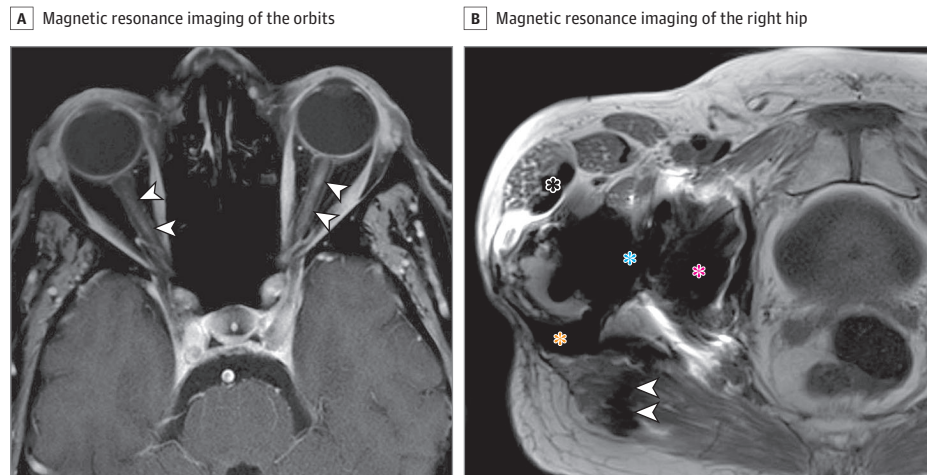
A, Axial postgadolinium, fat-suppressed, T1-weighted magnetic resonance image of the orbits, demonstrating left greater than right enhancement of the optic nerves (arrowheads). The enhancement is centrally located within the optic nerves on coronal sections (not shown). No other lesions were seen in the brain. B, Axial T2-weighted magnetic resonance image of the right hip, demonstrating susceptibility artifact of orthopedic hardware, as
